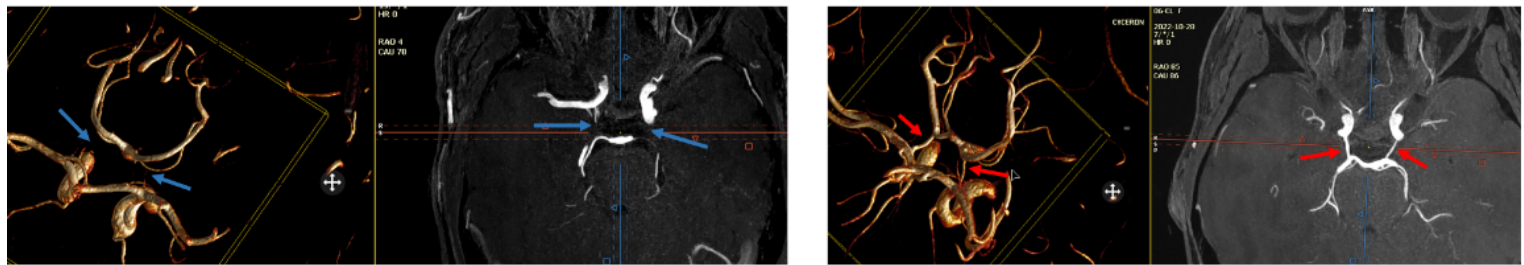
MRI of the Circle of Willis with incomplete arterial pattern to the left and full arterial pattern to the right
